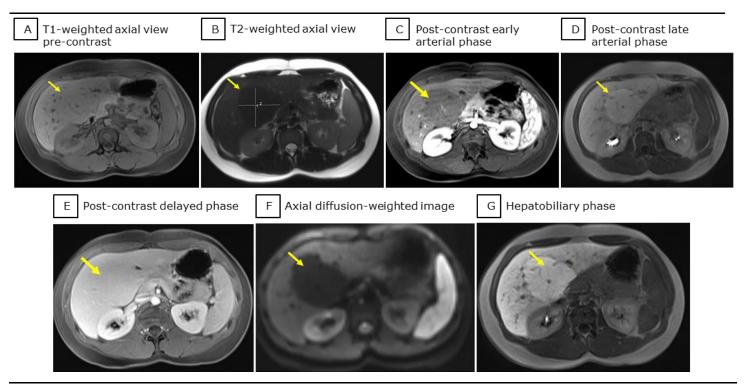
A Second Surveillance MRI (December 2018) of Abdomen with Gadoxetate Disodium.
